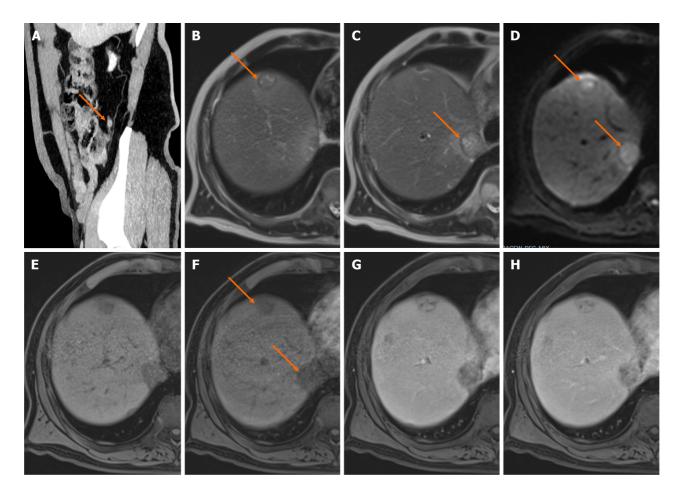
Liver metastases from an appendix neuroendocrine tumor. In Gd-DOTA-magnetic resonance imaging of a 60-year-old male patient. A: On sagittal MIP computed tomography images, there is an enhancing lesion located at the tip of the appendix (orange arrow); B and C: On consecutive T2-weighted images, lesions appear slightly hyperintense (orange arrows); D: Diffusion restriction in lesions on diffusion weighted imaging (orange arrows); E: Before contrast administration, lesions are hypointense; F: During the post-contrast late hepatic arterial phase, lesions appear hypovascular (orange arrows); G and H: Lesions are hyperintense on the portal-venous and delayed post-contrast phase.
